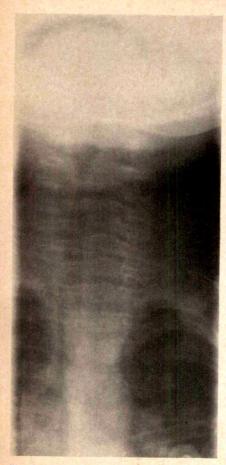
Anteroposterior neck roentgenogram demonstrating subglottic foreign body.
